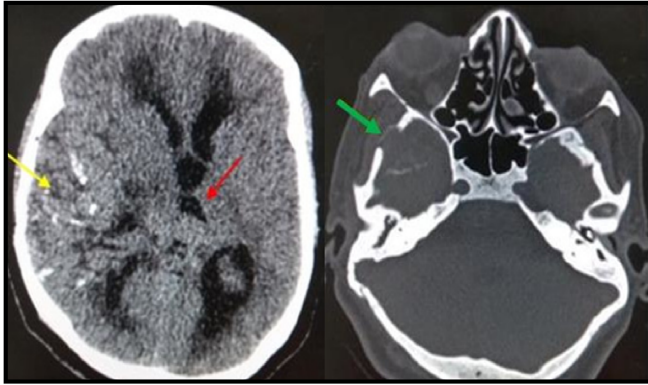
Non-contrast CT axial image of the brain showing an ill-margined hyperdense mass lesion having multiple specks of calcification in right temporo-parietal region [Yellow arrow] causing midline shift of 4.8 mm towards left side and mass effect upon right lateral ventricle and third ventricle resulting in obstructive hydrocephalus. [Red arrow]. Non-contrast CT axial image of the brain in bone window at level of the base of skull showing linear calcification foci in lesion of right temporal lobe along with cortical thinning and pressure erosion of right greater wing of sphenoid bone. [Green arrow] Right proptosis is also evident in this image.
